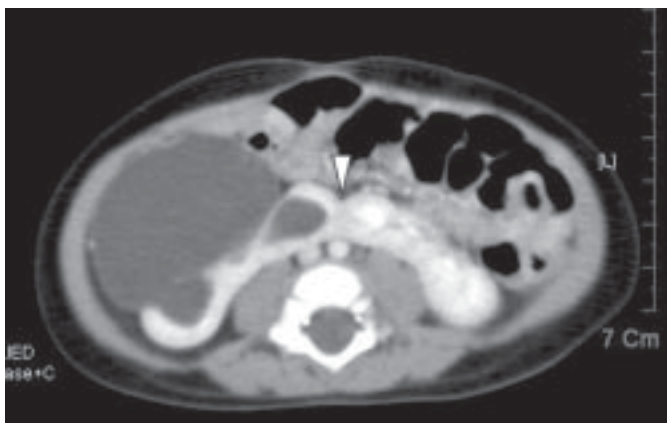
Transverse section of computerized tomography (CT) scan showing right and left renal parenchyma fused in the midline (arrow head).
